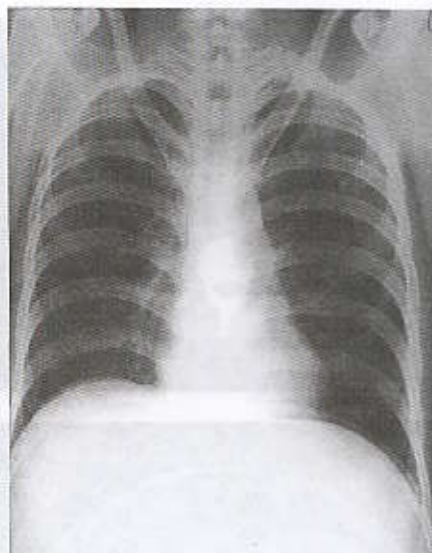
Chest radiograph shows no pulmonary infiltration or pleural lesion. Normal mediastinal structures and bony thorax are noted.
